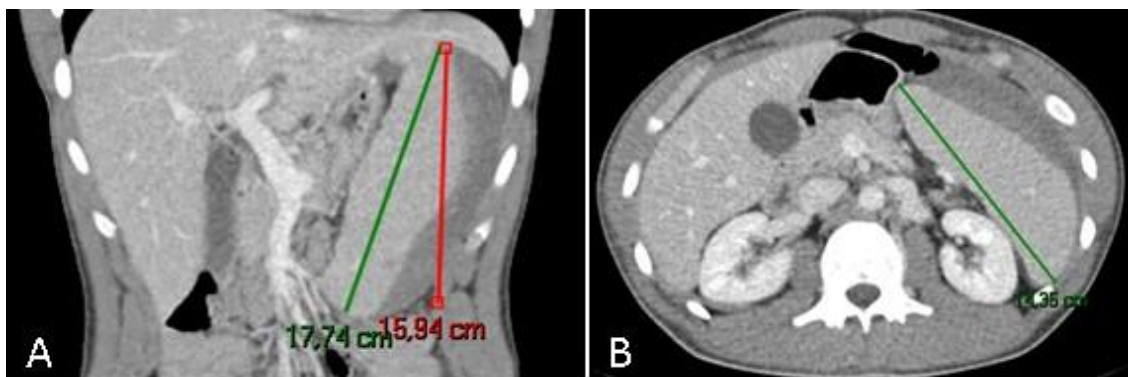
Enhanced abdominal CT scan showing: (A) a coronal section with Hmax = 17.74cm (green) and Hvert = 15.94cm (red) and (B) an axial section showing Lmax 14.35cm. Note: Hvert x Lmax = 228.58cm²
